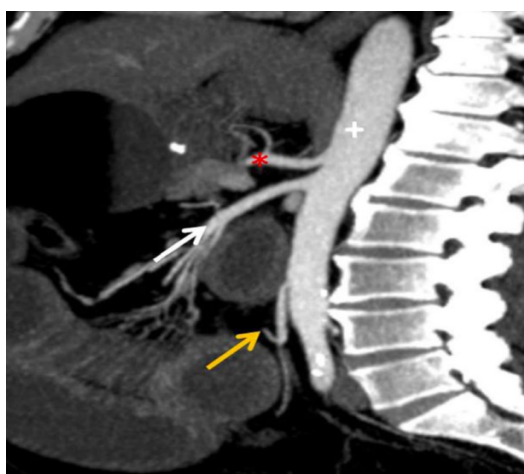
Main mesenteric artery anatomy on sagittal CT scan: celiac trunk (*), SMA (white arrow), IMA (orange arrow), abdominal aortic branch (+) ⁽¹⁾
